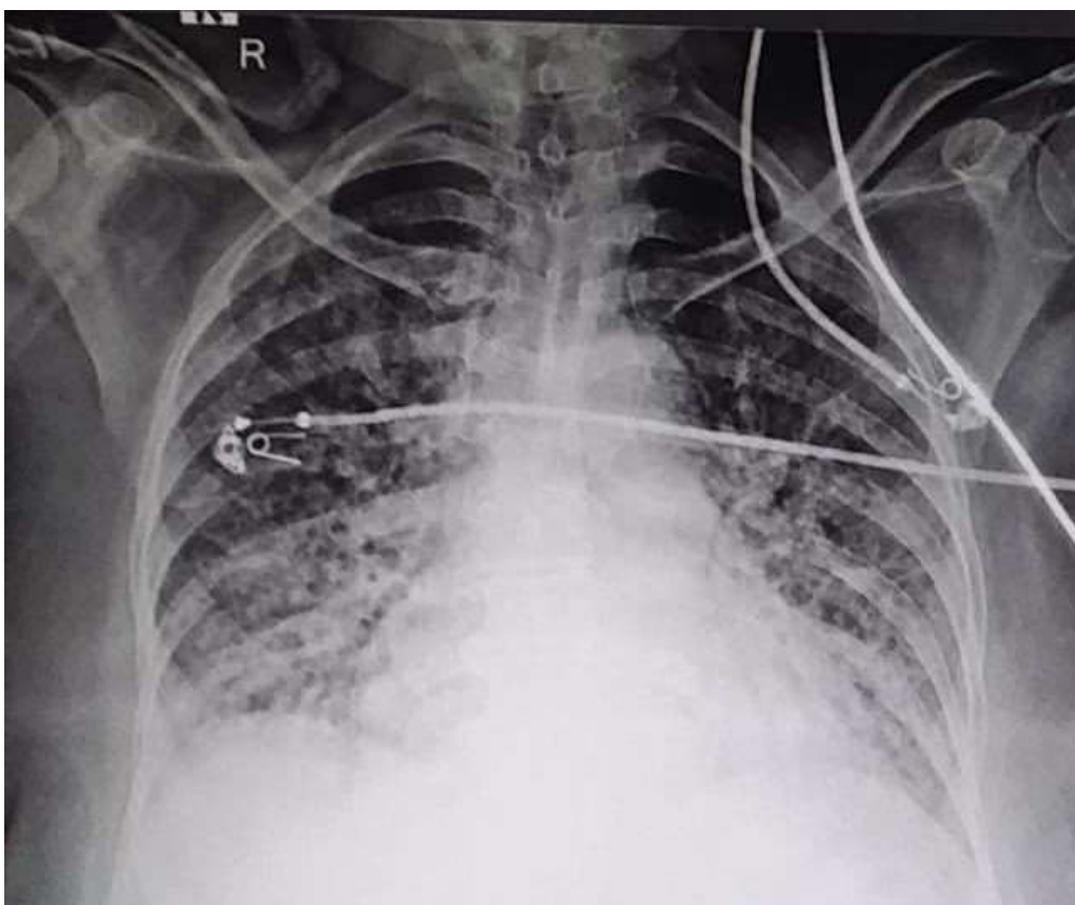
Baseline anterior-posterior view (AP) chest radiographs of case 2.
